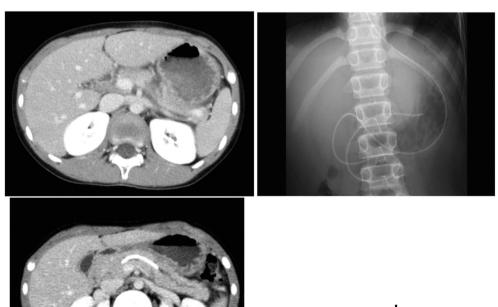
A: CT scan on day 1 shows pancreatic injury at body portion. 1-B: ERP was performed and ENPD tube (5fr) was placed. 1-C, D: X-ray and CT scan on day 26. ERP was performed and ductal stent was placed. (5Fr, 12 cm).
